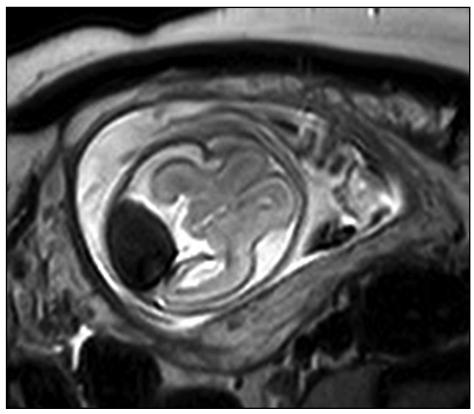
Fetal axial T2W MRI at 23 weeks and 4 days shows a torcular expansion with thrombus
